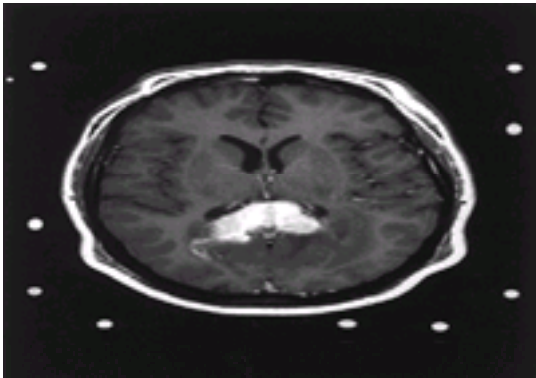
Axial T₁-weighted gadolinium-enhanced MRI showing a homogeneously enhancing, primary lymphoma of the central nervous system presenting in the splenium of the corpus callosum.
